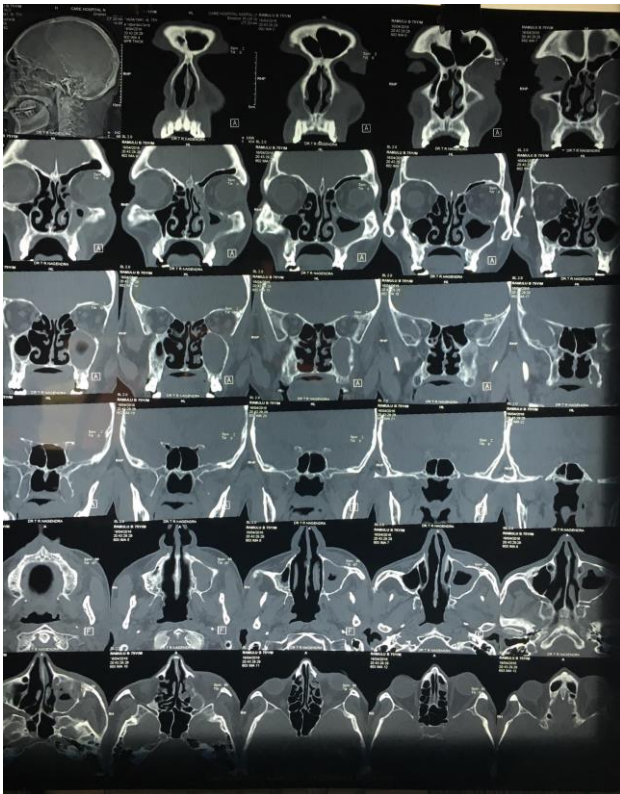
CT Scan maxillary sinusitis.
